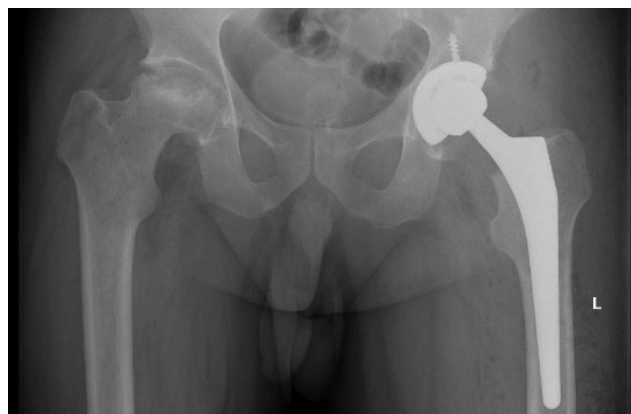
Anteroposterior radiographs of the hip joints: Left hip arthroplasty
